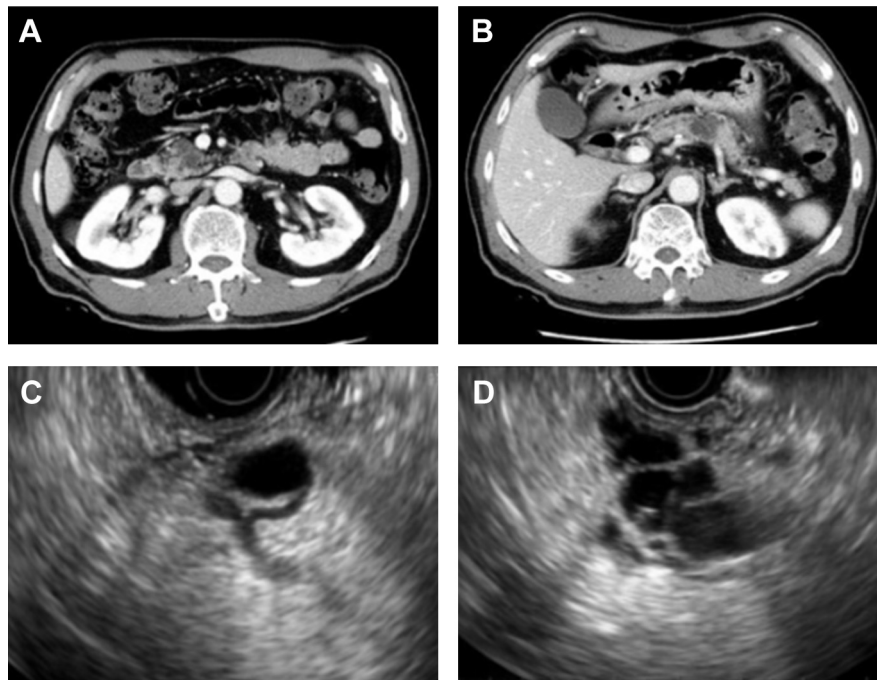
Branch-duct intraductal papillary mucinous neoplasm. (A, B) computed tomography showing a pancreatic cystic neoplasm at the head of the pancreas and pancreas body respectively. (C) Endoscopic ultrasound at the head of the pancreas showing a 3 cm septated cyst in communication with the pancreatic duct. The main pancreatic duct is mildly dilated, measuring up to 5 mm. (D) Endoscopic ultrasound at the pancreatic body showing a 2.7 cm multiseptated cyst.
